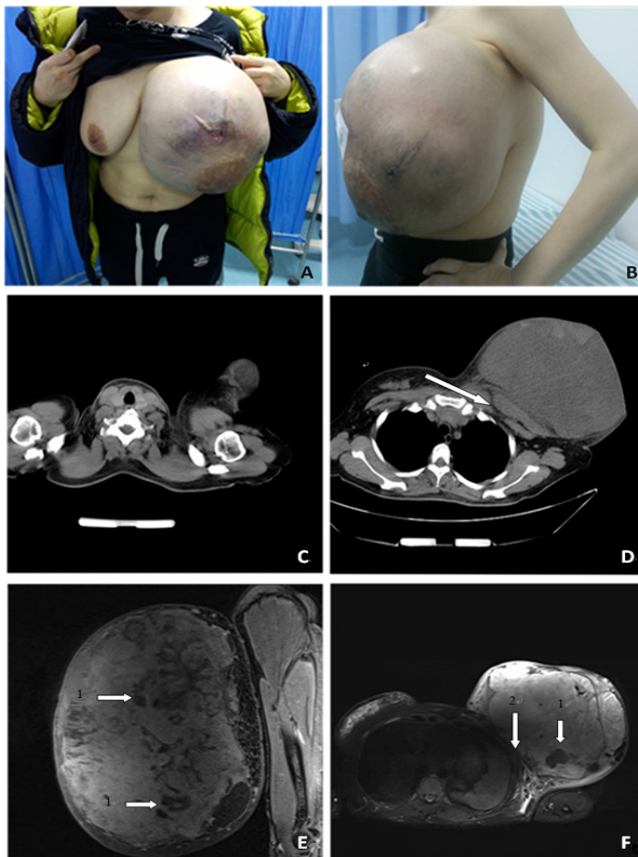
(A) Anteriorview of the breast tumor on presentation to our clinic; (B) Lateralview of the breast tumor on presentation to our clinic; (C,D) CT showed the chest wall was not involved (indicated by arrow (E,F) MR showed the giant tumor accompanied by multiple cystic part (indicated by arrows 1). Boundaries are still clear between the giant tumor and pectoralis (indicated by arrow 2).
